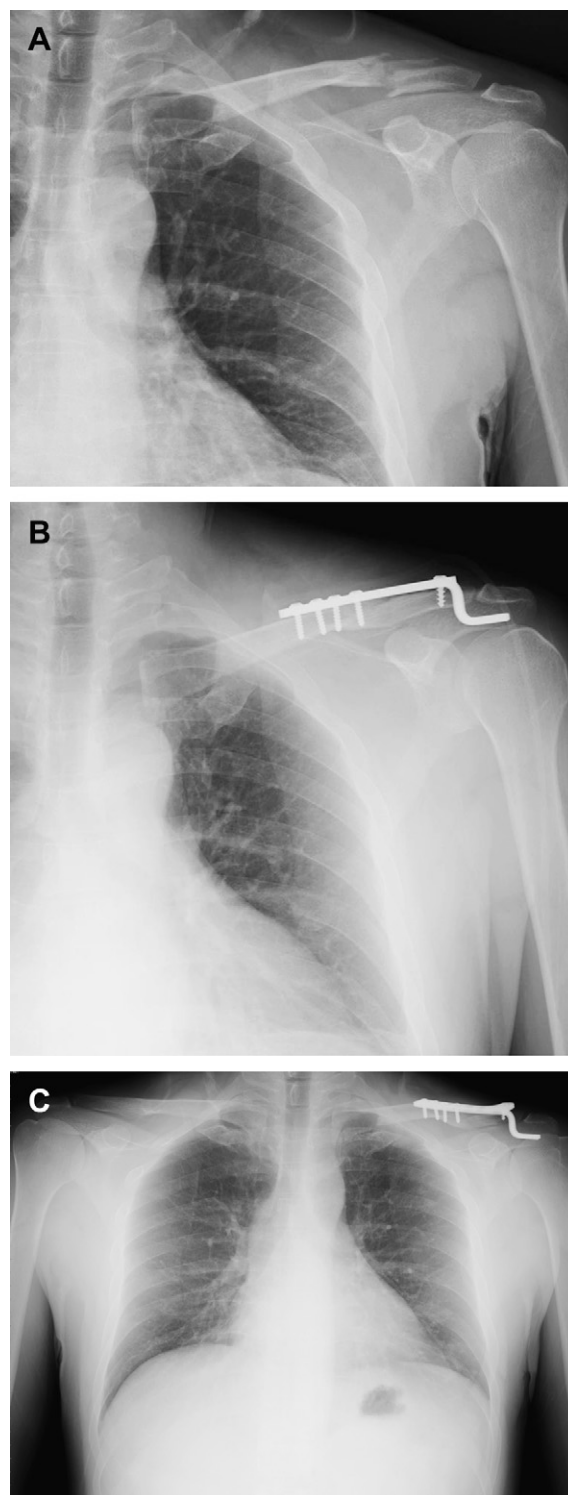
(A) Forty-one-year-old woman with a left distal clavicle fracture caused by an accidental fall. A vertical split parallel to the shaft with three fragments over the distal end of the clavicle are noted. (B) Postoperative X-ray showed Hook plate fixation for Neer Type 2c fracture with adequate fixation and stability. (C) Good bone union (3 months postoperatively).
